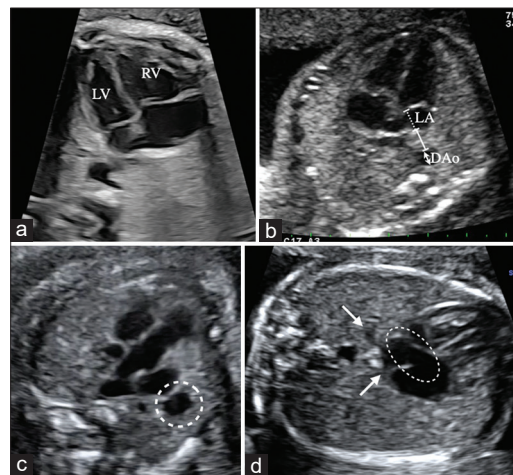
Two-dimensional ultrasonic images of indirect sonographic markers for fetal total anomalous pulmonary venous return (TAPVR) on B-mode. (a) Ventricular disproportion at 35 weeks of gestation: In this case, supracardiac TAPVR was diagnosed through the second-trimester screening; however, ventricular disproportion (right ventricle > left ventricle) was not apparent until 35 weeks of gestation, (b) Increased distance between the left atrium (LA) and the descending aorta (DAo) at 23 weeks of gestation: In the apical four-chamber view, the post-LA space index was calculated as the ratio of the distance from LA to DAo (solid line calipers) to the diameter of the DAo (arrow calipers). The left-atrial posterior-space-to-diagonal ratio was calculated by dividing the distance from LA to DAo (solid line calipers) by the diameter of the LA (dotted line calipers), (c) Dilated superior vena cava (SVC) (supracardiac type) at 26 weeks of gestation: Because of the excess blood flow from the vertical vein draining into the SVC, the SVC becomes as large as the aorta (dashed line circle), (d) dilated coronary sinus (coronary sinus type) at 23 weeks of gestation: The pulmonary veins (arrows) connect to the dilated coronary sinus (dashed line circle) instead of the LA. This plane is caudal to the true four-chamber view plane because the atrioventricular valves are not seen clearly. RV: Right ventricle, LV: Left ventricle, LA: Left atrium, DAo: Descending aorta
